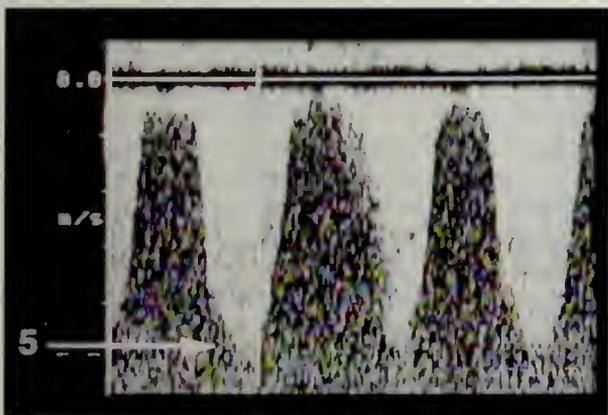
A continuous-wave Doppler flow signal of tricuspid regurgitation is obtained from transthoracic echocardiography in a patient with severe pulmonary hypertension due to a ventricular septal defect. The peak flow velocity of 5 m per seconds corresponds to an estimated pulmonary artery systolic pressure of 100 mm of mercury.
